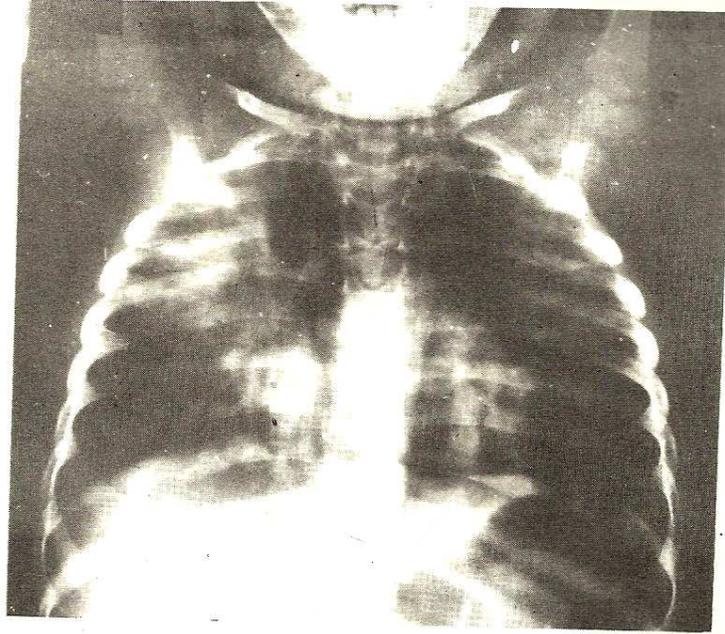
Chest radiograph showing a right upper lobe segmental consolidation with pneumomediastinum. Lung aspirate yielded *Klebsiella* spp.
